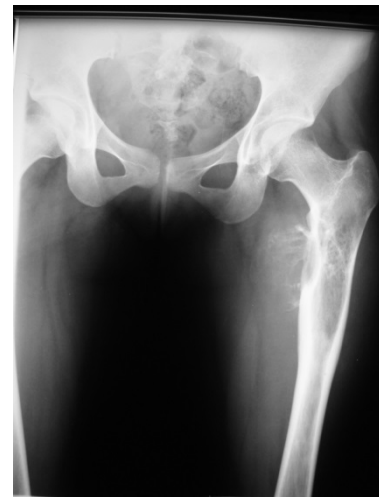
Antero posterior radiograph showed expansile, eccentric lytic lesion in the proximal femur with extension to soft tissue
